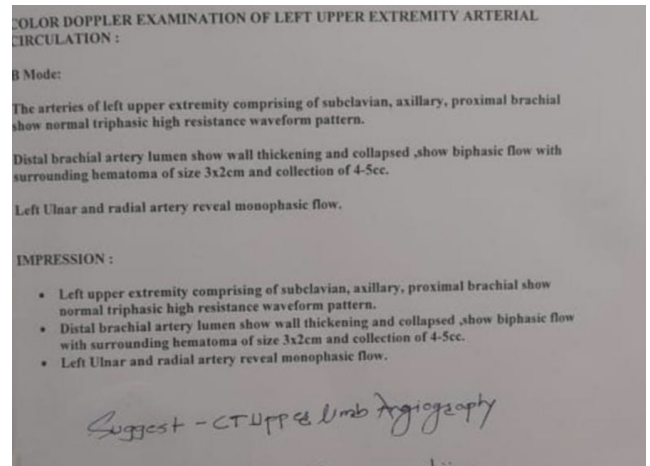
Pre-op colour doppler report of left upper extremity
